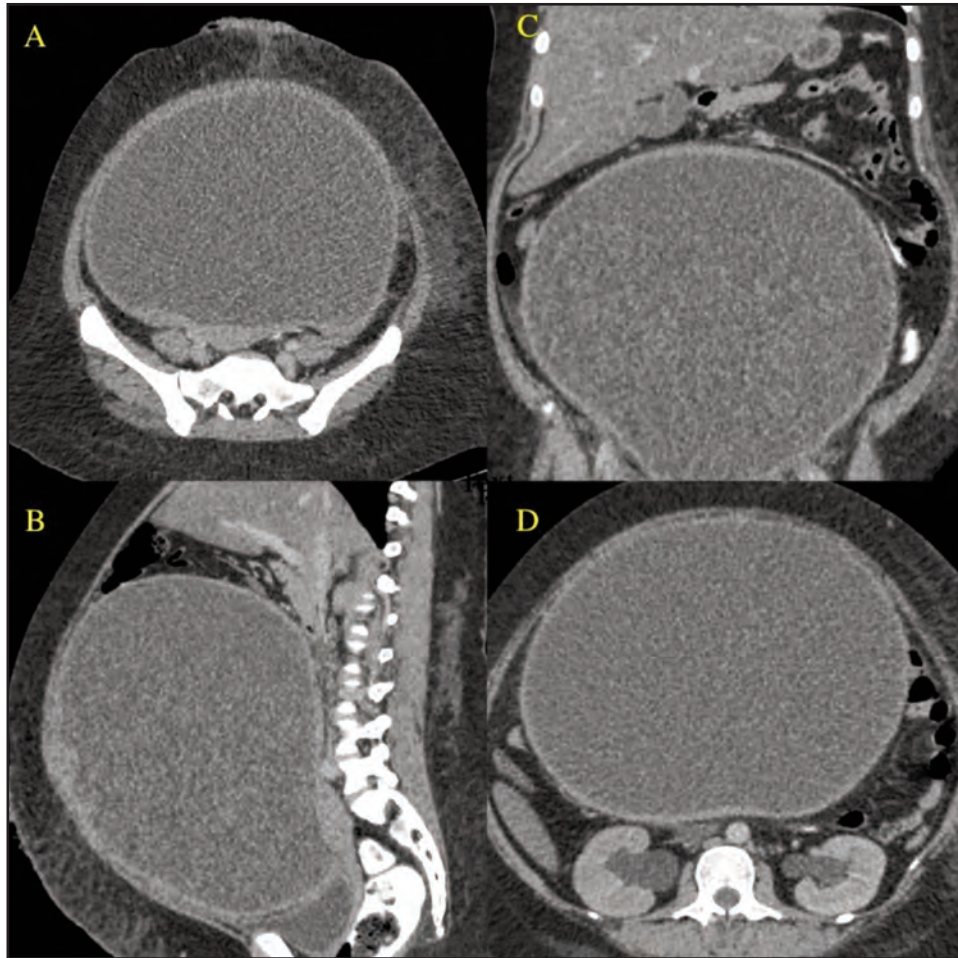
CT TAP findings. A: transverse view at pelvic level. B: Sagittal view, showing displacement of visceral organs superiorly. C: Transverse view at hepatosplenic level. D: transverse view at renal level showing mild hydronephrosis. CECT abdomen and pelvis in axial, coronal and sagittal views showing a huge peripherally enhancing unilocular cystic mass measuring 20.7 x 28.3cm x 27.8cm (AP x W x CC) arising from pelvis till right subhepatic region. There is no septation, papillary projection, calcification enhancing solid or fat component within. It results in bilateral mild hydronephrosis.
